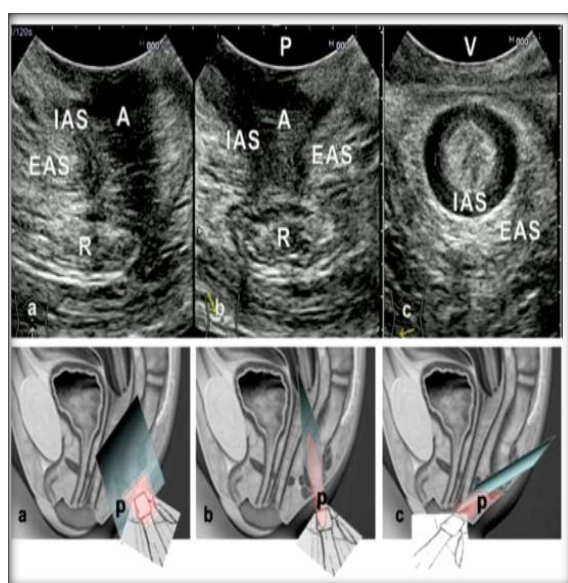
Transperineal ultrasound evaluates the perianal region using three primary imaging planes: (a) sagittal, (b) coronal, and (c) axial or transverse
